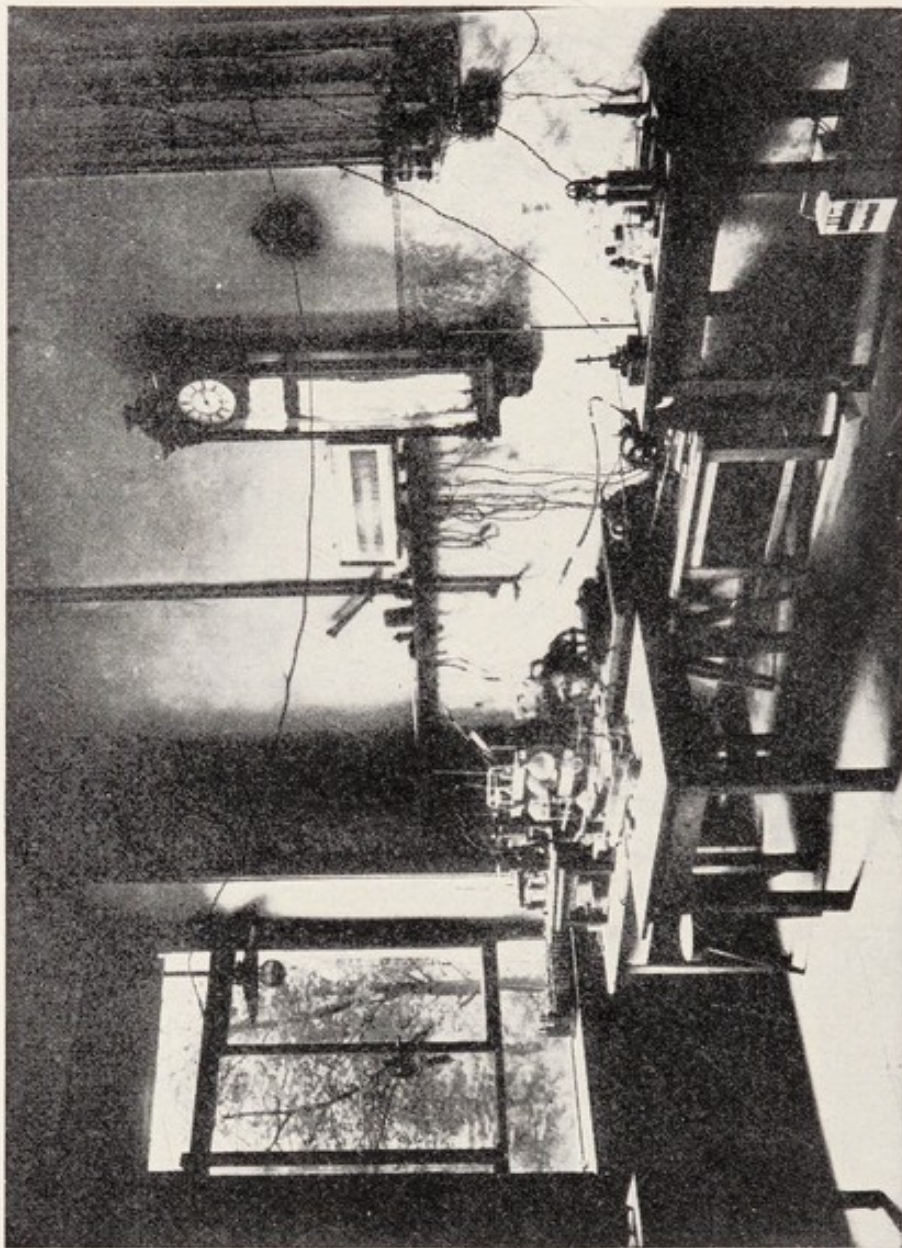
Interior of Roentgen's laboratory at Würzburg. The laboratory is in active use today but is said to be practically unchanged.
